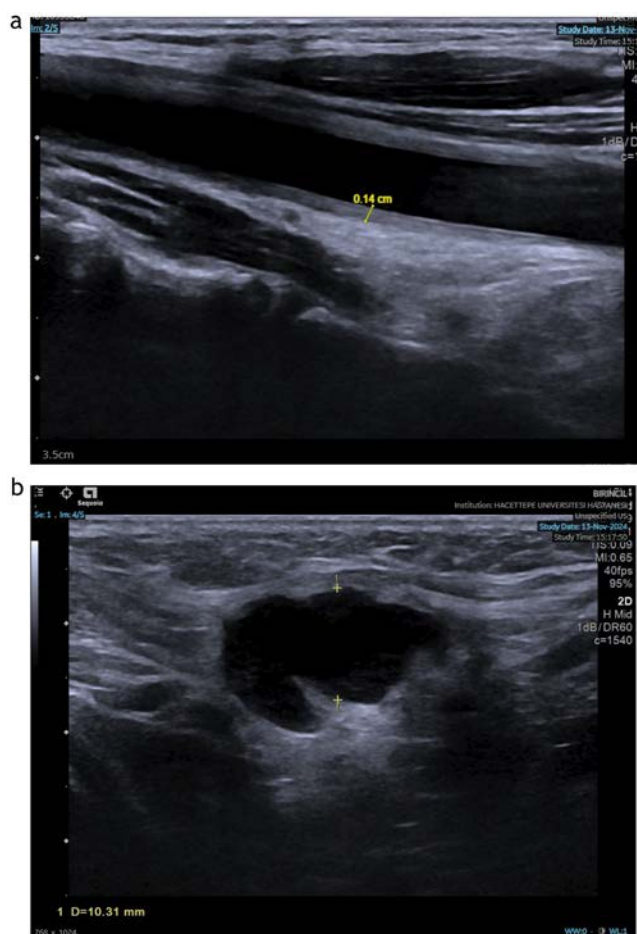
(a) Right carotid ultrasound imaging in longitudinal plane (pre-treatment). This ultrasound image shows a longitudinal view of a blood vessel, most likely an artery, with a visible hypoechoic (dark) thickening along the vessel wall. The measured thickness is 0.14 cm (1.4 mm), which may indicate early signs of vessel wall thickening. (b) Right carotid ultrasound imaging in transverse plane (pre-treatment). The ultrasound images demonstrate a hypoechoic, well-defined, hypoechoic perivascular thickening within the carotid artery region, measuring approximately 10.31 mm in diameter. The transverse and longitudinal views reveal vessel wall thickening with potential evidence of inflammatory involvement.
